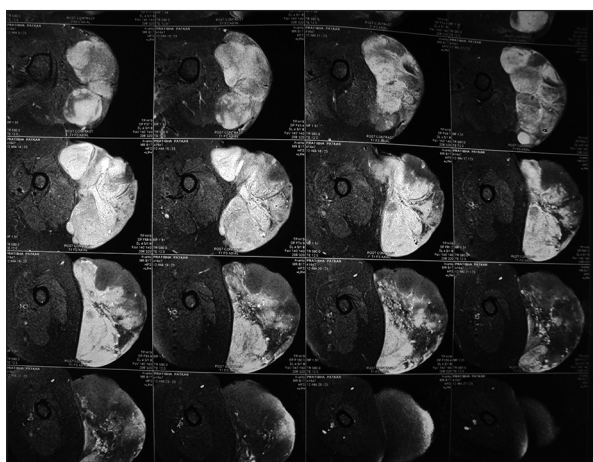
Magnetic resonance imaging scan showing tumour superficial to the deltoid muscle
